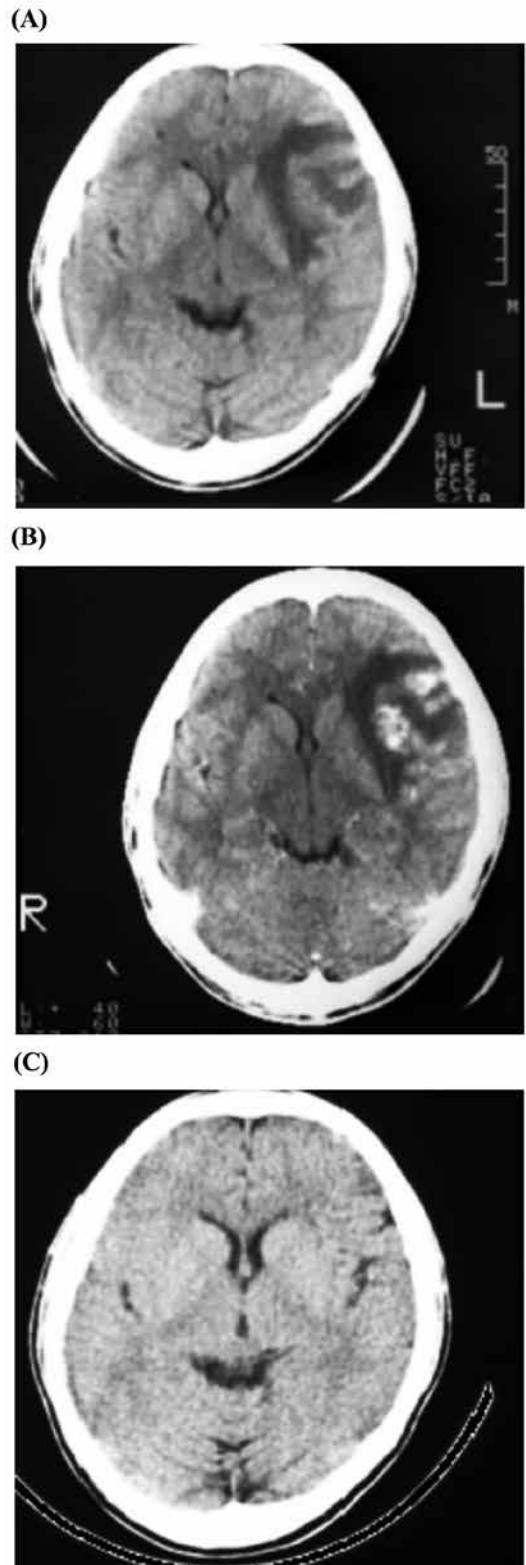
Brain X-ray computer tomography scan of patient with chronic cerebral schistosomiasis japonica.
